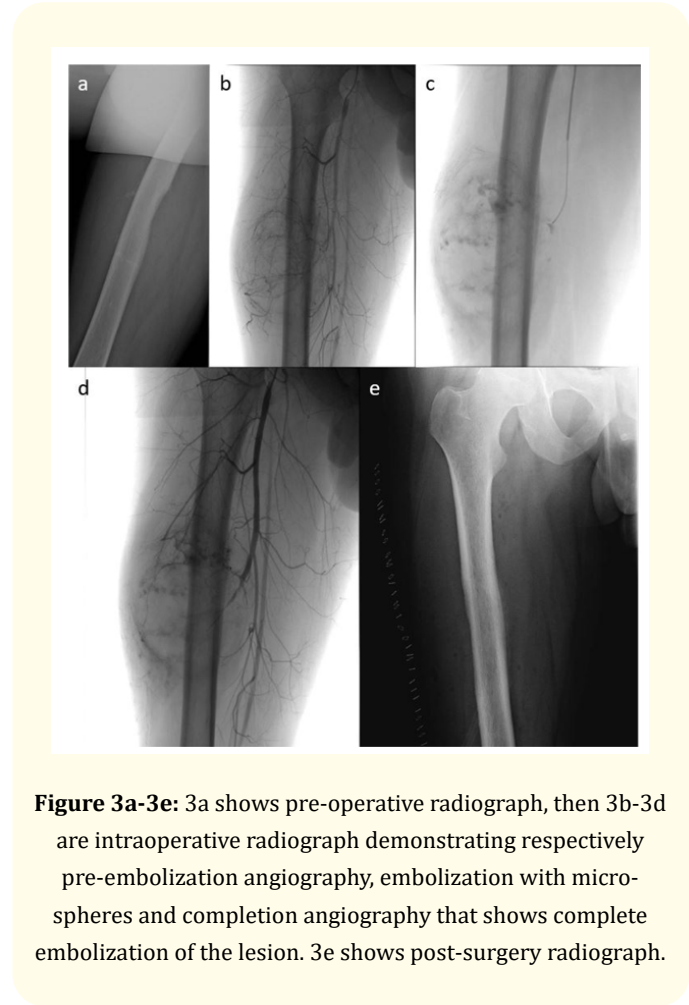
3a shows pre-operative radiograph, then 3b-3d are intraoperative radiograph demonstrating respectively pre-embolization angiography, embolization with micro-spheres and completion angiography that shows complete embolization of the lesion. 3e shows post-surgery radiograph.
